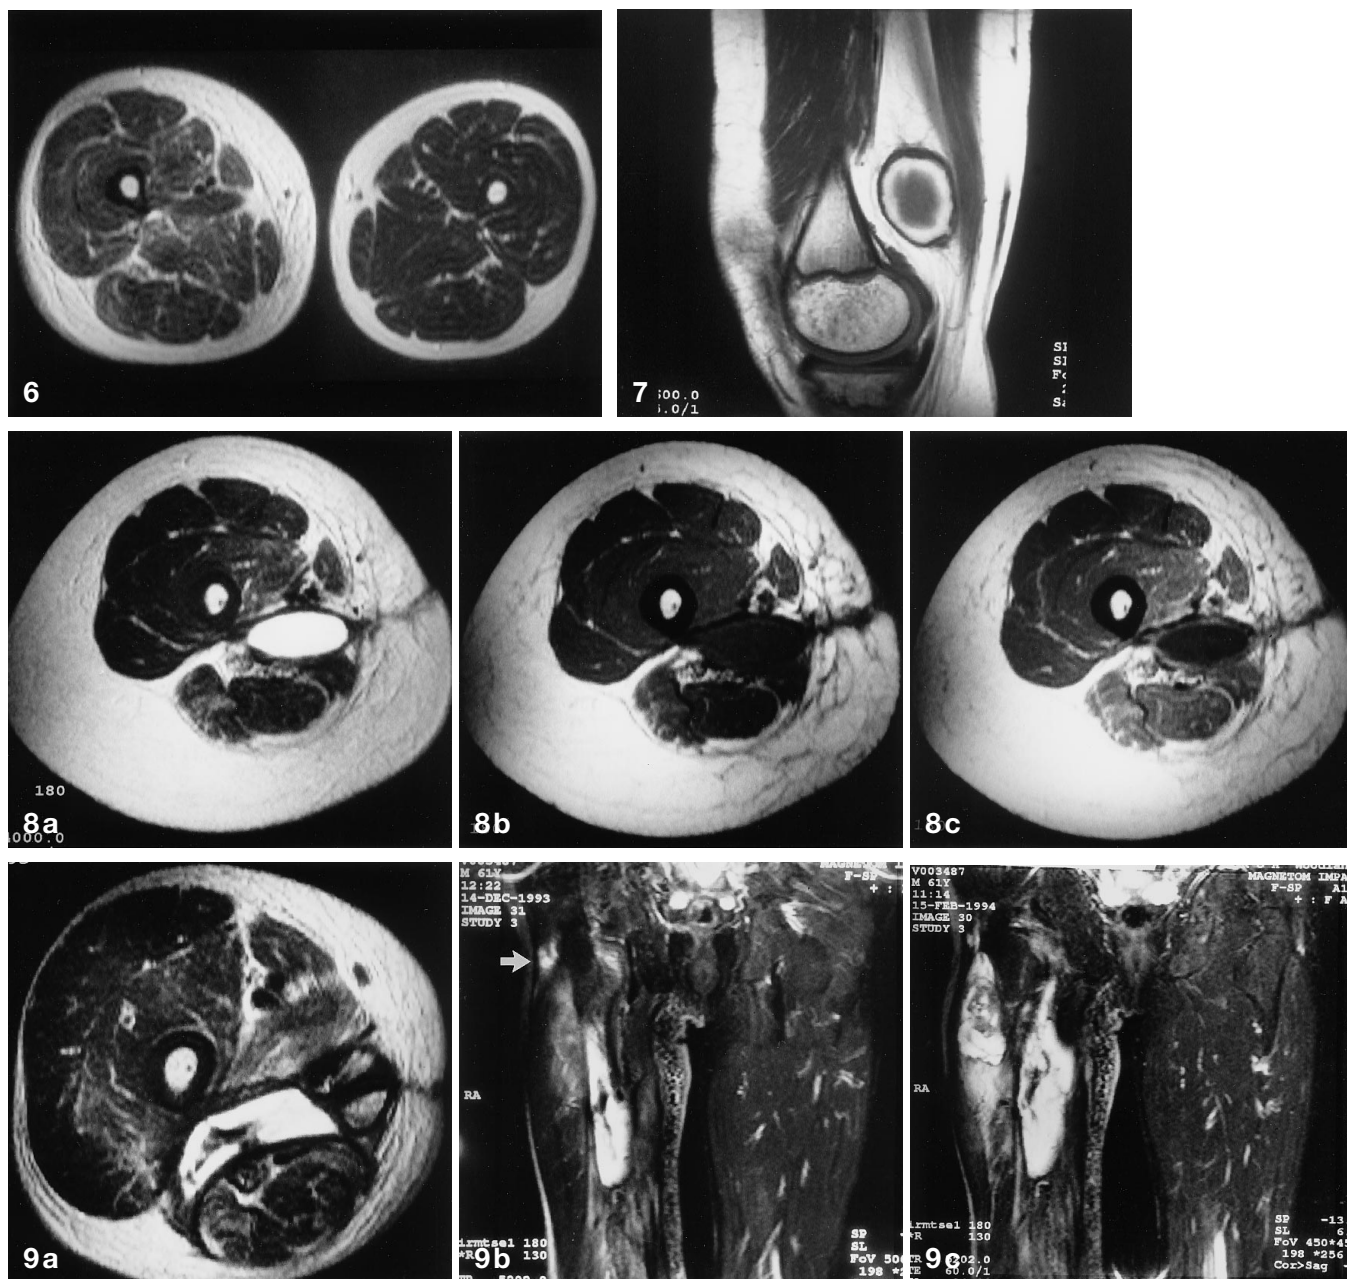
A 32-year-old female 2 years after surgical excision and postoperative radiotherapy for soft tissue sarcoma right thigh. Axial T2-weighted image through both thighs showing diffuse swelling and edema of the right thigh secondary to the radiotherapy
